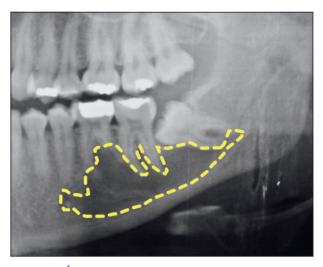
Panoramic radiograph image showing a well-demarcated, radiolucent, unilocular lesion with scalloped margins in left mandible (yellow dashes). The lesion infiltrates the second molar region and causes a remarkable resorption in the distal root of the first molar.
